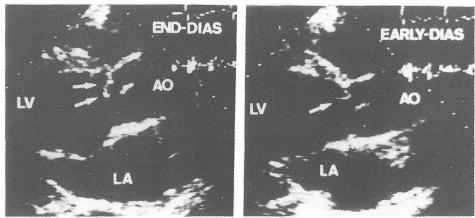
Echocardiographic long-axis views of the heart; An enigmatical movement of the right coronary cusp (white arrow) of the aortic valve. A right coronary cusp seems to originate from the true annulus suggesting a cusp prolapse in this figure.
